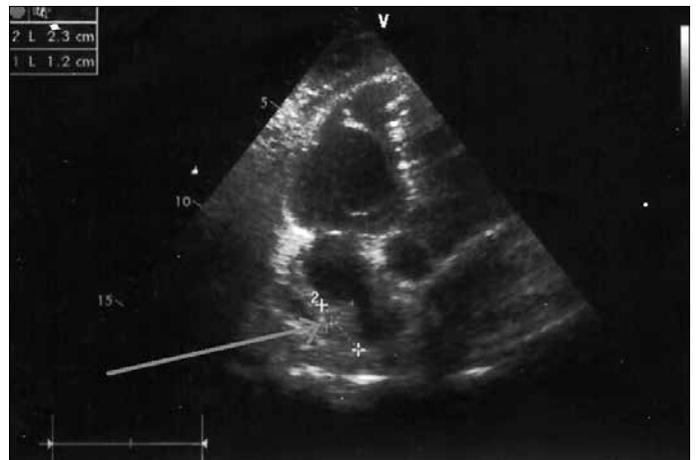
Showing a right atrial mass in Echocardiography
